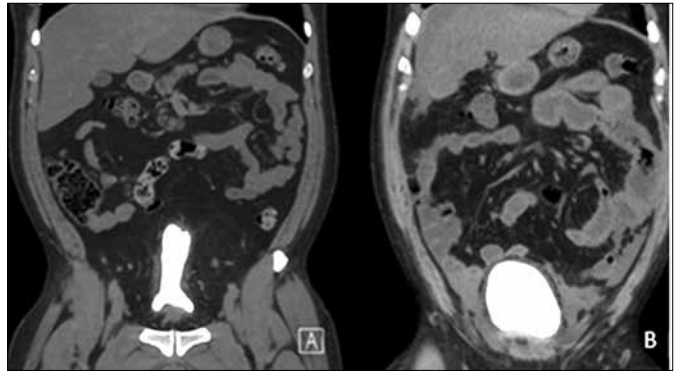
A. CT Cystogram showed excessive fat deposition around the bladder and elongated bladder. B. Marked reduction of fatty tissue around the bladder and globular contour of the bladder (post-operative).
